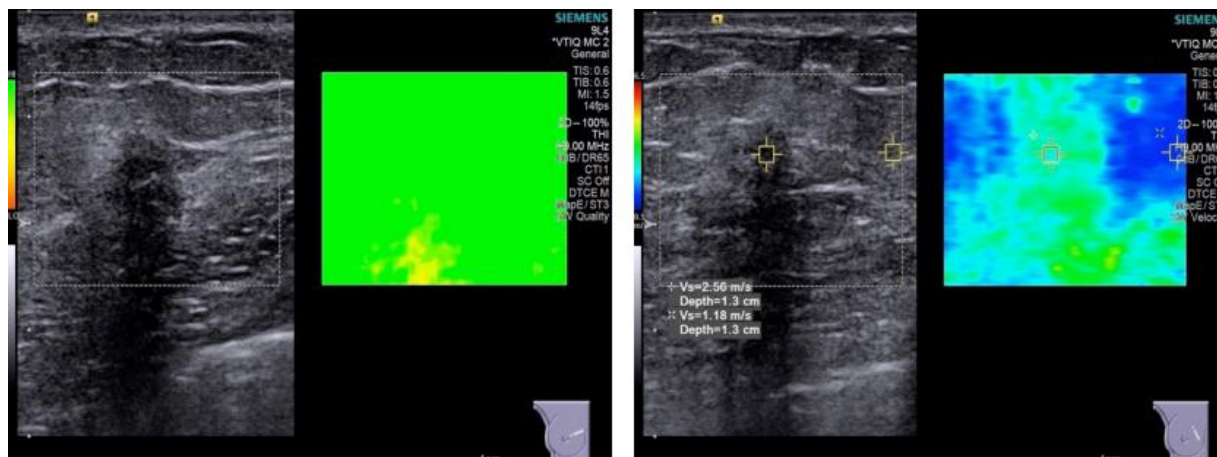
Sonography showed a spiculate hypoechoic nodule, with slight posterior acoustic shadow and it measures 13 mm.
